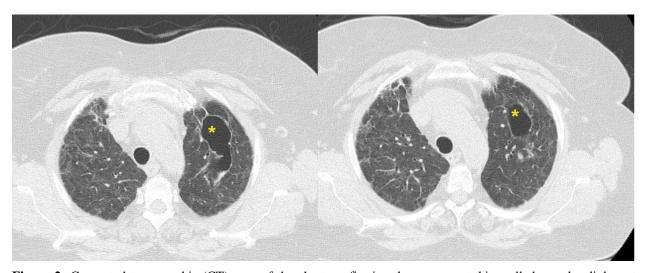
Computed tomographic (CT) scan of the chest confirming the new-onset thin-walled round radiolucent lesions consistent with pneumatocele (star).
